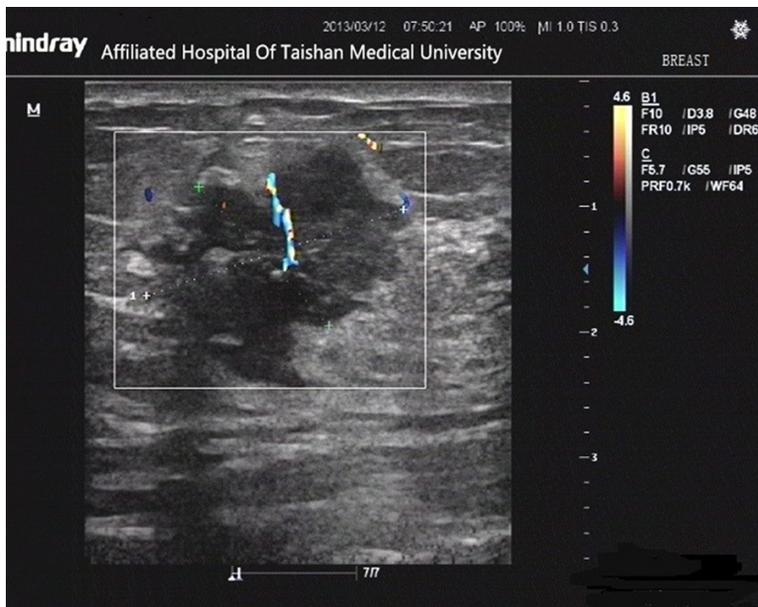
Ultrasound of a BC patient with vascular abnormalities.
